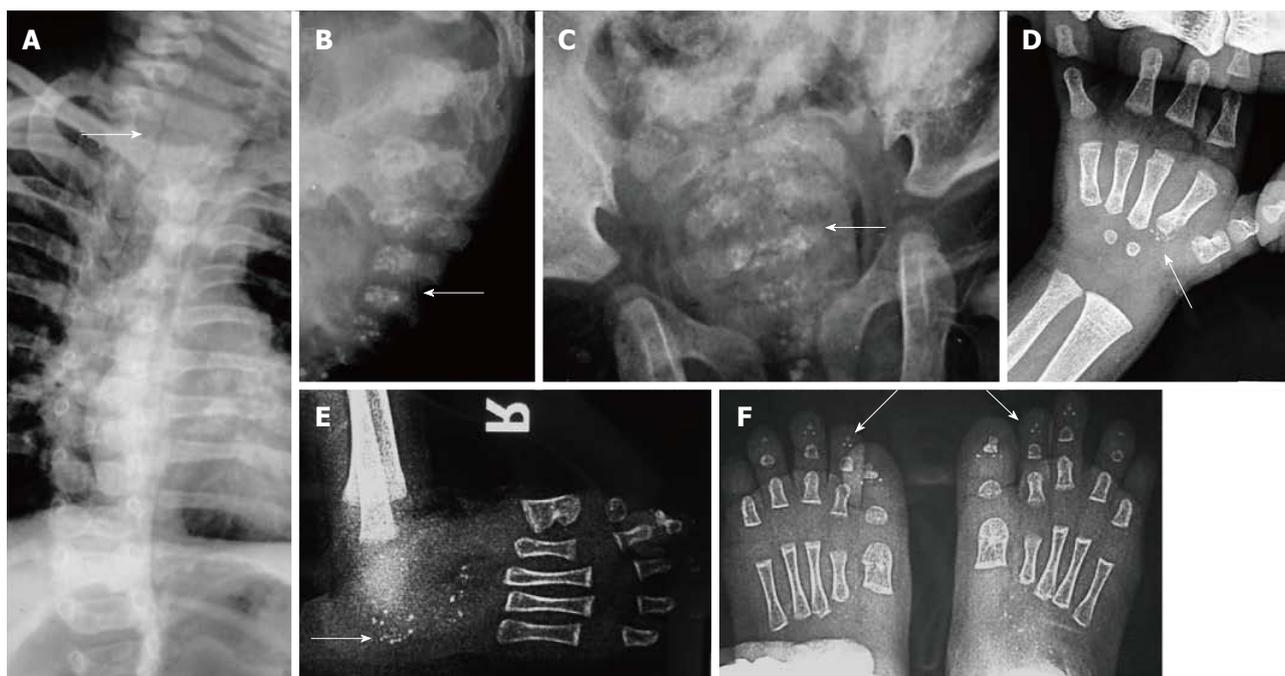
Chondrodysplasia punctata. Oblique view radiograph of dorsal spine (A) shows coronal clefting (arrow). Radiographs of another patient with chondrodysplasia punctata show stippling of vertebral bodies (arrows B, C), in toes (D), tarsal bones (E) and in carpals (F).
